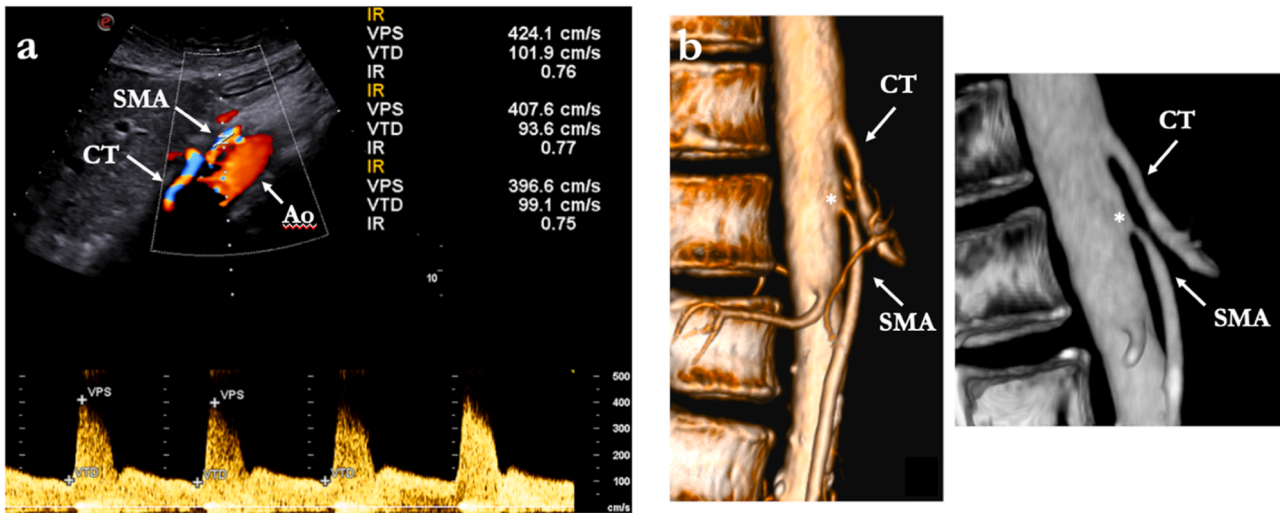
DUS (Fig. 1a) and CTA (Fig. 1b) of a patient with superior mesenteric artery stenosis.
